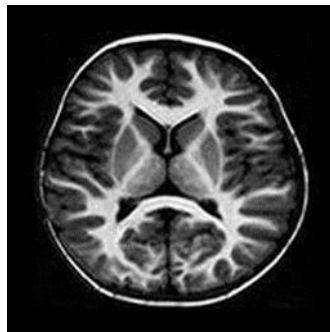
MRI Scan of Normal Brain
